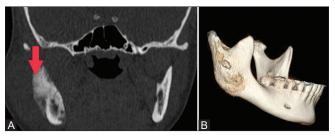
(A and B) (A) Coronal CT reconstruction of mandible show proliferative periostitis (red arrow). (B) 3-D reconstruction of mandible show proliferative periostitis
